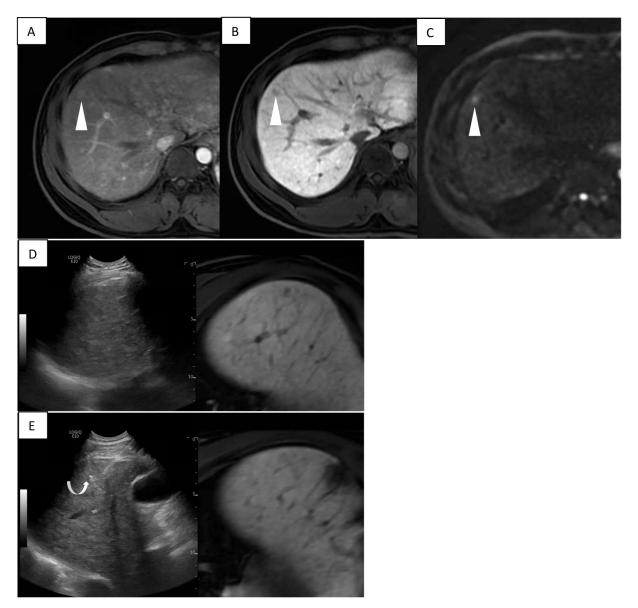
Nodule invisible on ultrasound
